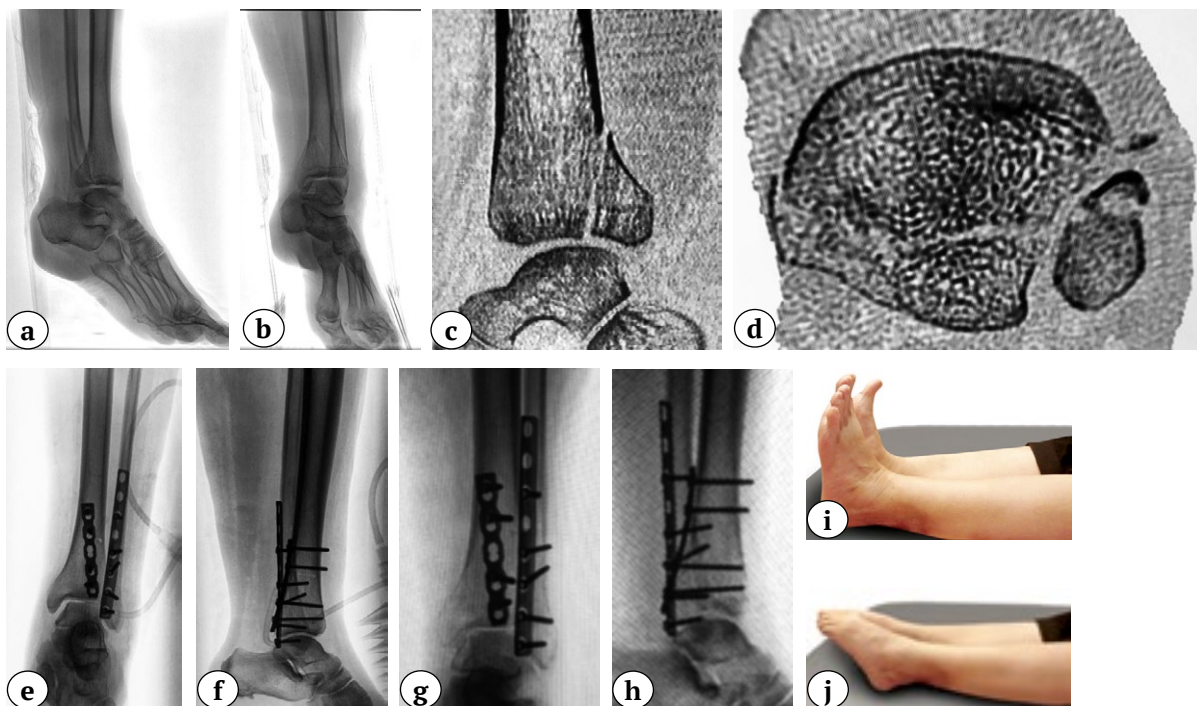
Excellent result of surgical treatment of patient 58 y. o. with a 44-B3 fracture after osteosynthesis: a, b – primary X-rays in AP and lateral views; c, d – CT scans show the size of the posterior edge of the tibia; e, f – postoperative X-rays in AP and lateral views – anatomical reduction of the ankle joint; g, h – X-rays 3 months after injury – consolidation of fractures; i, j – functional result within 12 months after injury
